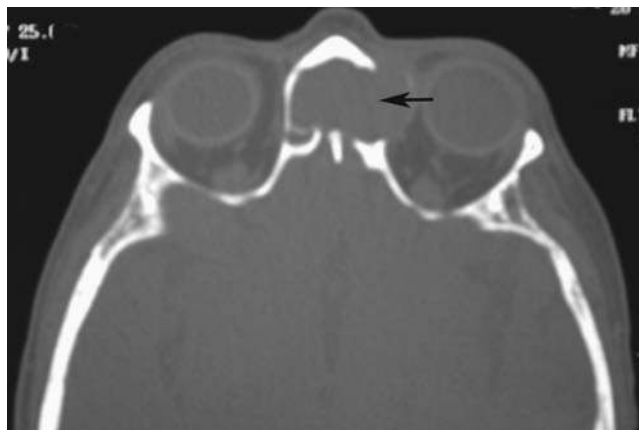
Sinus mucocele. Axial CT exhibiting sinus opacification and bone erosion (arrow). Abbreviation: CT, computer tomography. Source: Courtesy of John DelGaudio, M.D., Emory University, Atlanta, Georgia.
